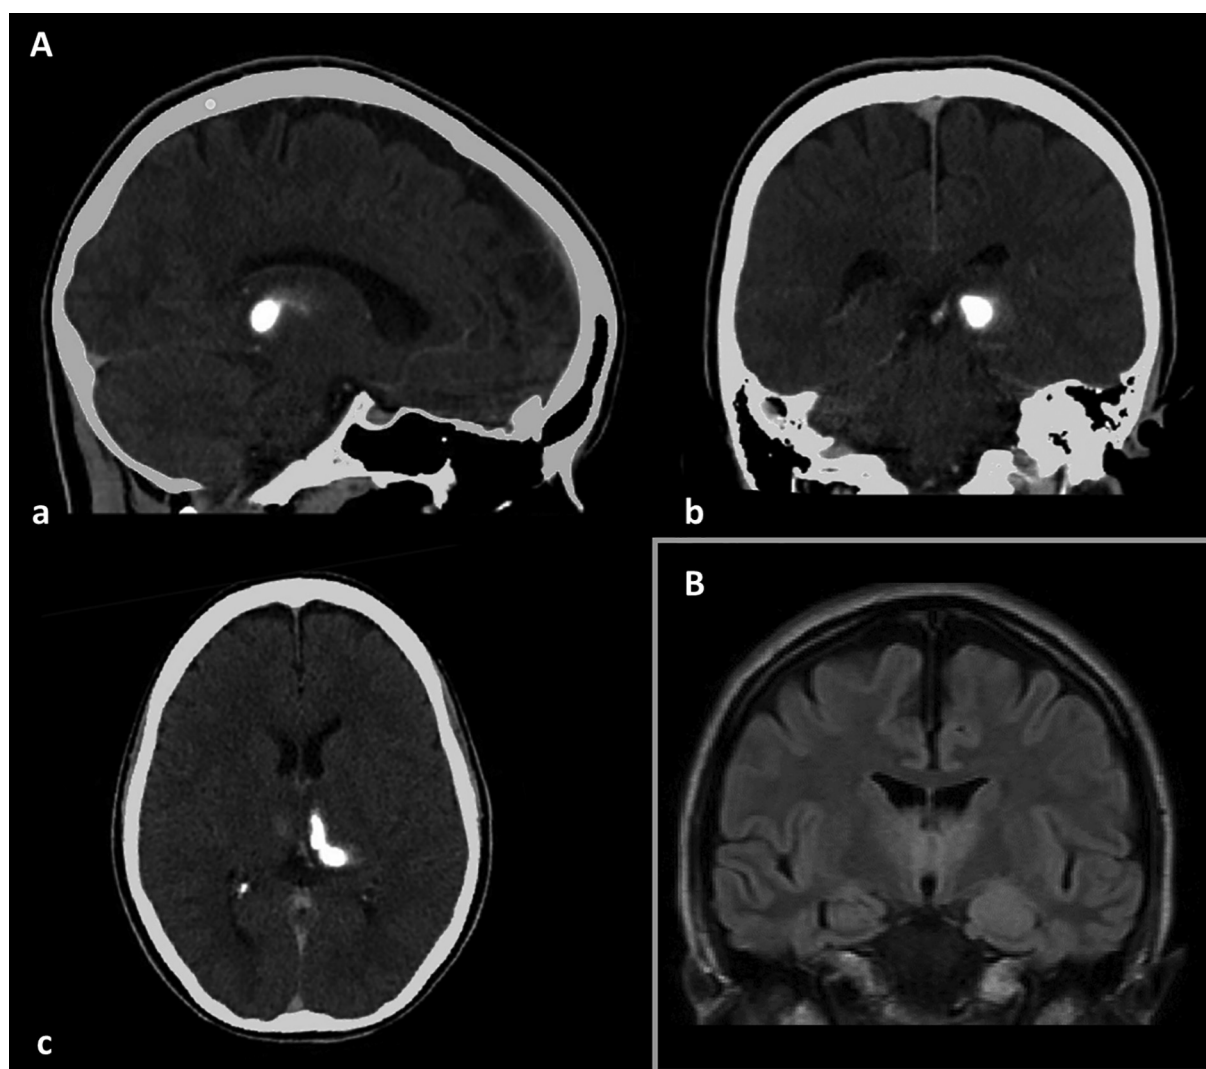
A. CT-scan showing brain calcifications on sagittal (a), coronal (b) and axial (c) views. B. MRI showing both amygdalae on a coronal view, with the left bigger than the right one.
